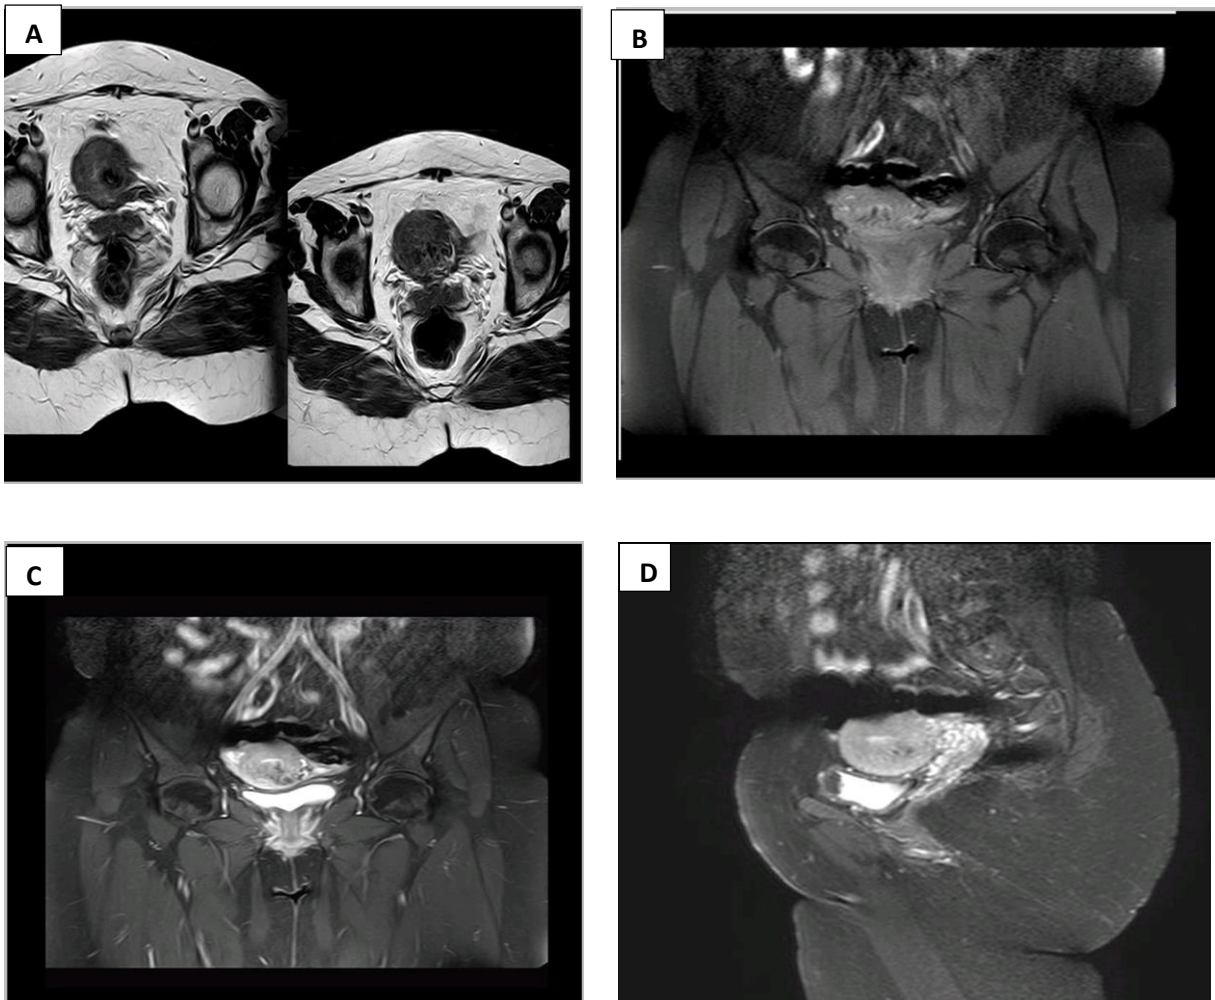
(A) Axial T2 & (B) coronal T1-weighted fat-suppressed imaging of the pelvis shows numerous tortuous vascular flow voids in the myometrium. (C) Coronal & (D) sagittal fat-saturated gadolinium-enhanced T1-weighted MR images of the pelvic shows lobulated tortuous lesion within the myometrium & parametrium that is strongly enhancing.
